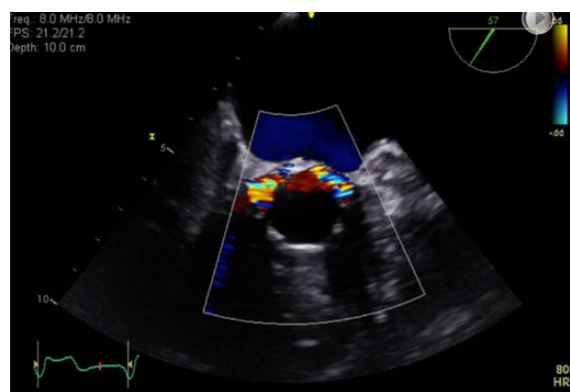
Transverse (short-axis) colour Doppler image of the LVOT immediately below the TAVI valve. Paravalvular regurgitation is seen from the medial to the lateral aspects of the valve involving almost 40% of the circumference.
